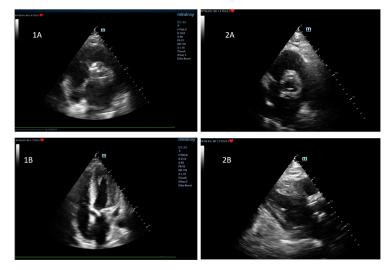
b.8 Morphological aspects of aortic valves before (1A: calcified valves, parasternal short axis, 1B: 4-chamber view) and after surgery (2A: normal opening of aortic prosthesis, parasternal short axis, 2B: normal opening of aortic prosthesis, parasternal long axis)
